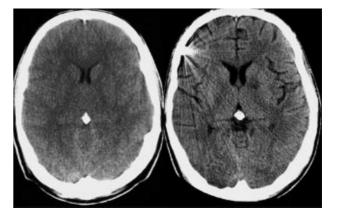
Effects of early extracorporeal detoxification (FPSA-Prometheus[®]) in a patient with ecstasy/cocaine induced ALF and refractory cerebral edema. Transplantation was declined due to active injection drug abuse. Comparison of cranial computed tomography scans obtained before (arterial ammonia, 318 µmol/L, left) and after 4 days of continuous treatment (arterial ammonia, <50 µmol/L) demonstrates restoration of gray-white differentiation and normalization of sulci and ventricles width. Note ischemic infarcts of left internal capsule and occipital cortex and metallic artifact of epidural transducer.
